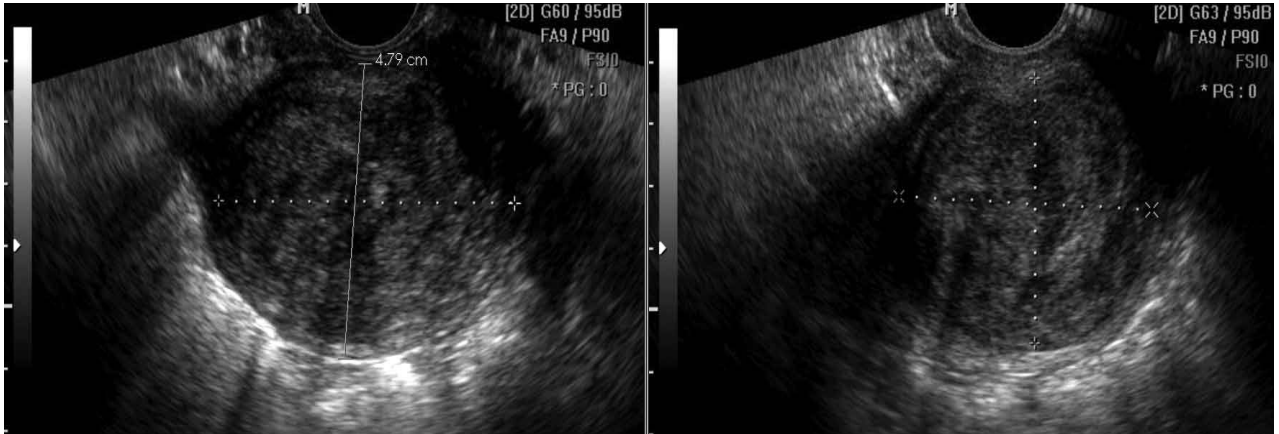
Fibroid - (www.ultrasound-image.com)
